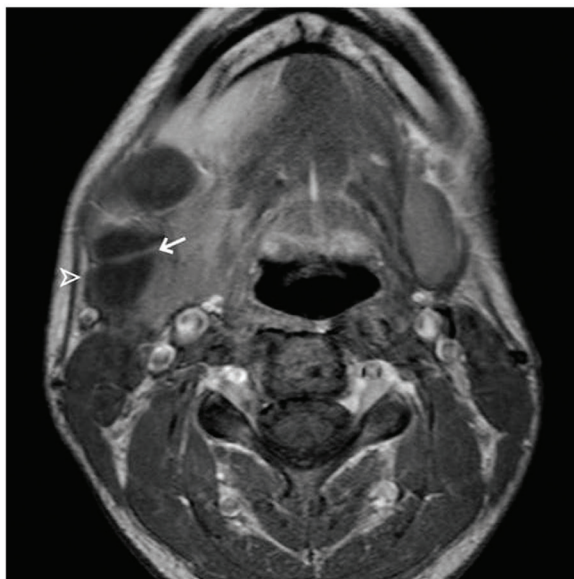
Axial Post-Gd T1 W MRI shows an uncomplicated lymphatic malformation in the right submandibular region (Δ). Note the thin enhancing septa (→).
